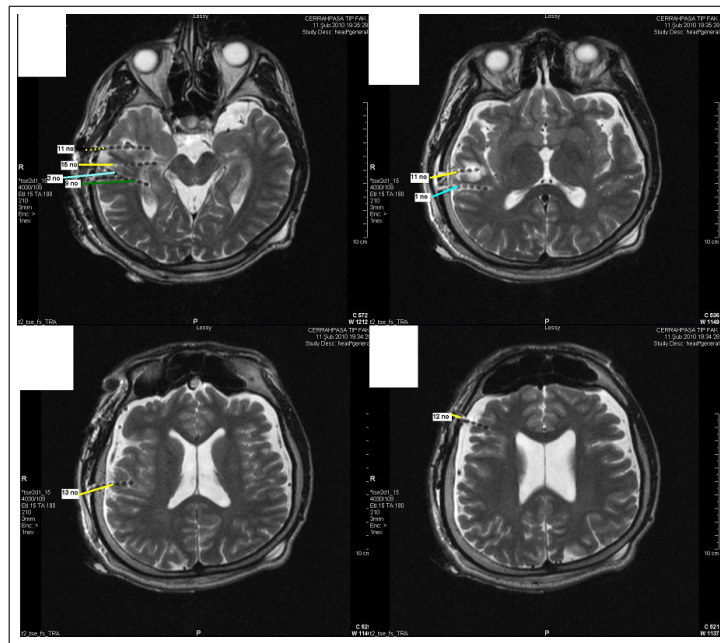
Postoperative T2 weighted MR images. The locations of the deep electrodes are shown with colored markers (64 contacts).
